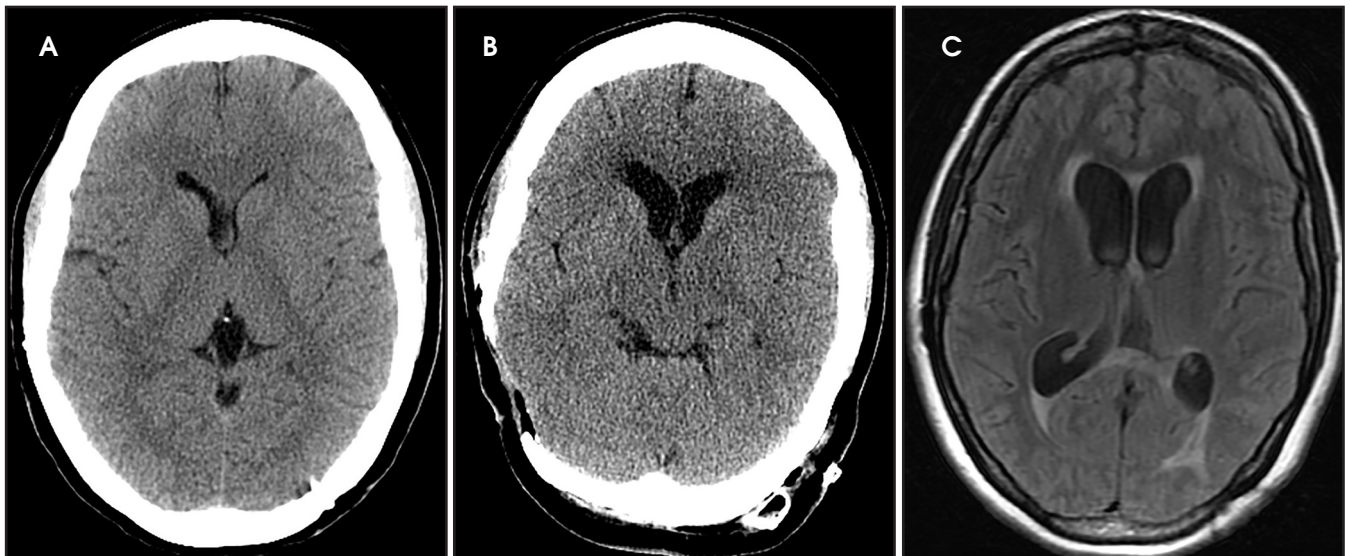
Noncontrast CTs (A) several days and (B) several months after SAH demonstrate development of hydrocephalus. (C) Periventricular FLAIR hyperintensity represents transependymal flow.
